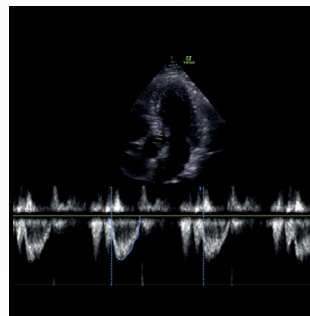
Tracing consecutive PW Doppler waveforms.
